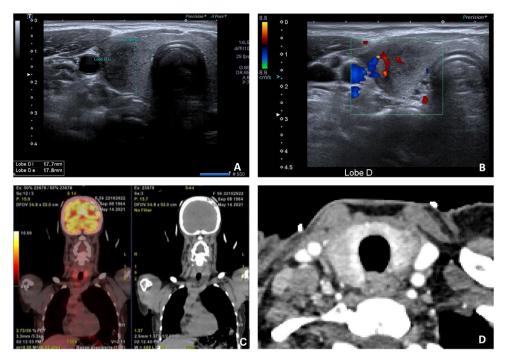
Thyroid imaging. A. Thyroid ultrasonography images of patient 1. Focal hypoechoic area on the right lobe. B. Thyroid ultrasonography images of patient 2. Decreased blood flow on Doppler USG in the right lobe except for one healthy part in the middle. C. PET/CT of patient 1, showing thyroid uptake. D. Thyroid CT showing hypodensity on both thyroid sides.
